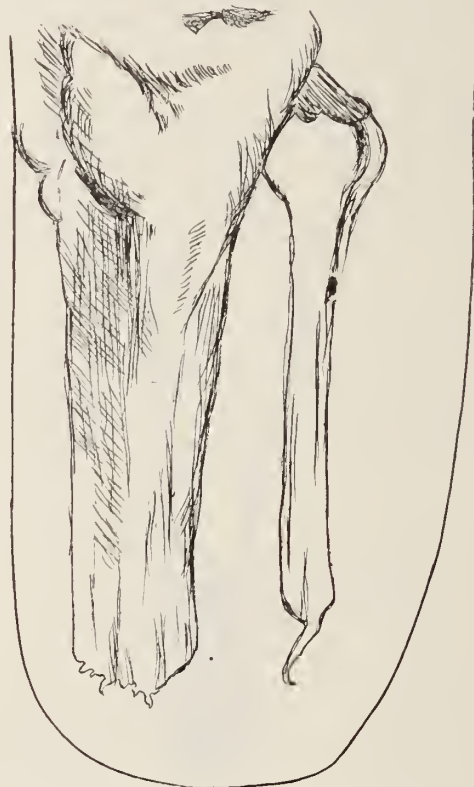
Spicules resulting from exostosis (drawn from X-ray picture.)
